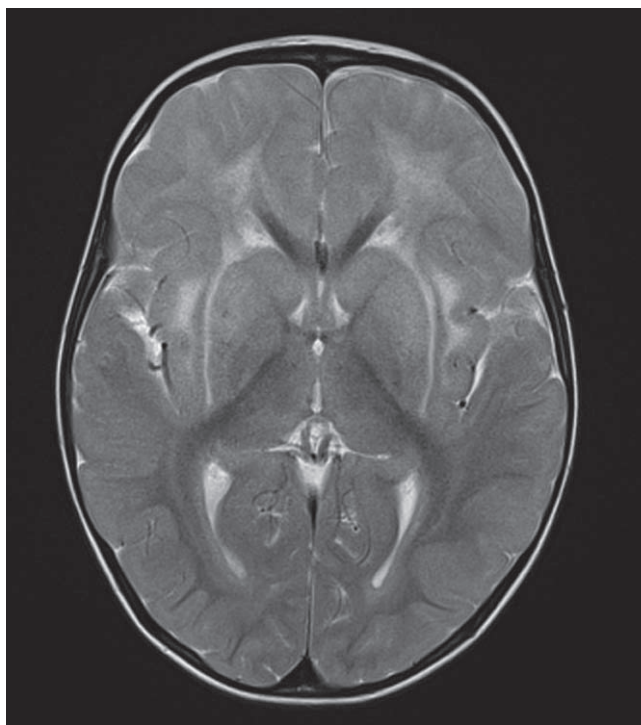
MRI of patient 5 with infantile/childhood form with milder clinical course of the disease. White matter lesions with frontal predominance on T2 sequence. See also narrowing of the lateral ventricles and pericerebral spaces due to swelling of basal ganglia.
